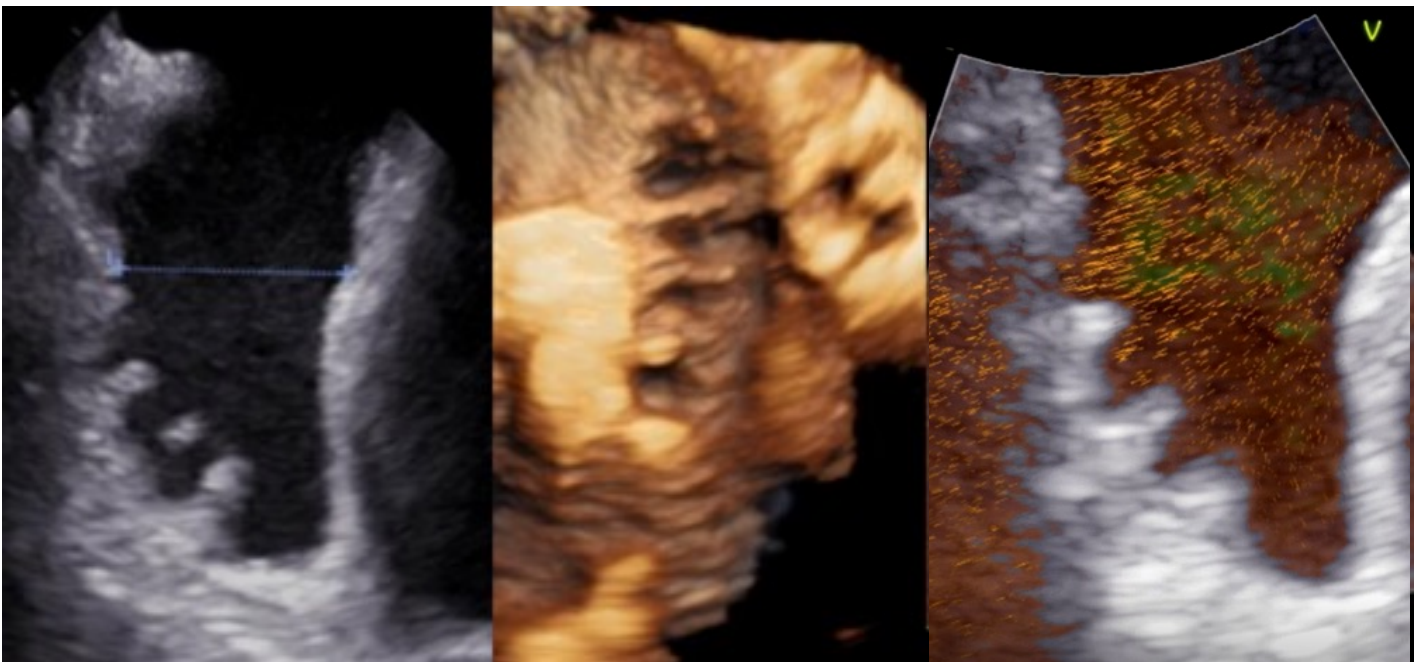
Left atrial appendage with prominent pectinate muscles and deep recesses by 2D (left) and 3D (center) transesophageal echocardiographic imaging. Blood speckle imaging (right) confirms the presence of moving blood cells in these deep recesses.
